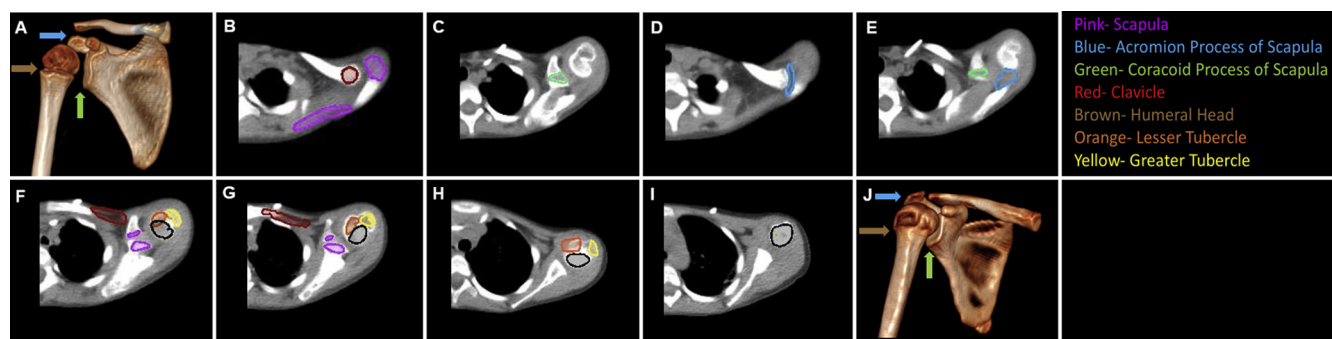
Important ossification centers of the shoulder depicted on an anterior (A) 3-dimensional reconstructed computed tomography scan of a 5-year-old female patient. Axial computed tomography slices show contours of important centers for growth (B-I), progressing in the craniocaudal direction. Growth is nearly complete, with ossification centers fused, in the depicted scan from a 14-year-old male patient (J).
